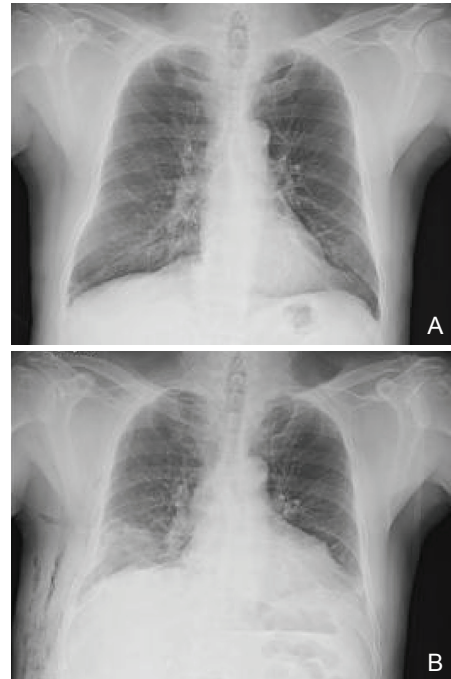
A: The first chest plain film at the emergency department. B: The second chest plain film on the next day. There was an infiltrative patch at the right lower lobe, complicated with subcutaneous emphysema.
